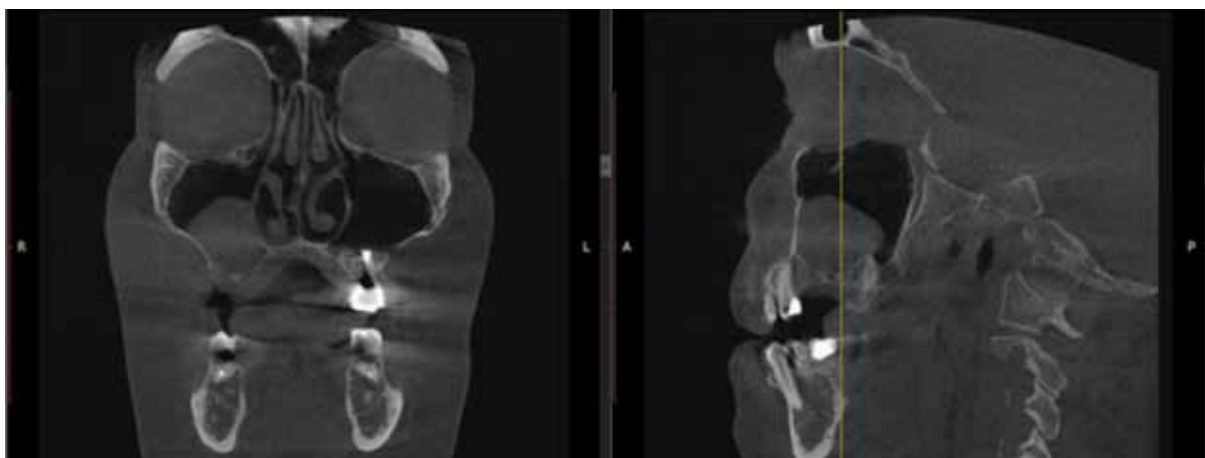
Reformat of cone-beam computed tomography of a patient who has been diagnosed a cyst of the maxillary sinus
